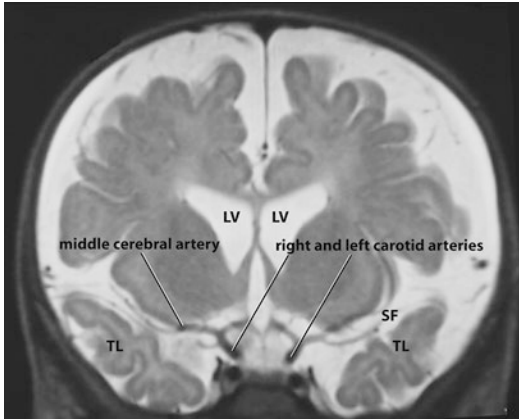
Coronal MRI at the level of the sylvian fissure (SF) showing the free communication of the subarachnoid space from the base of the skull to the convexity on either side and how the main blood vessels travel in the subarachnoid space. The carotid arteries divide into anterior cerebral and middle cerebral arteries. The left and right anterior cerebral arteries are linked by the anterior communicating artery and two posterior cerebral arteries are linked to each carotid via the left and right posterior communicating arteries, thus making up the circle of Willis—the arterial ring that supplies blood to the brain. (LV lateral ventricle, SF Sylvian fissure, TL Temporal lobes)
